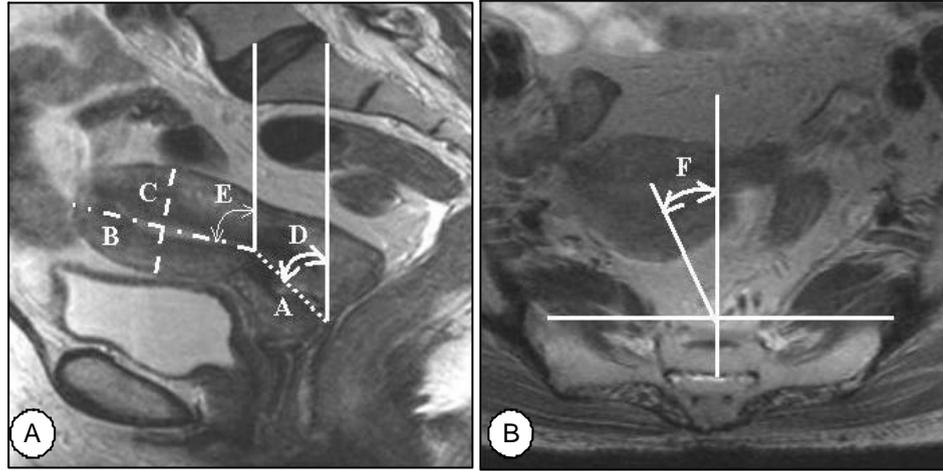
Sagittal and axial images on T2 weighted MRI showing the measurable parameters of the uterine corpus and cervix. (A) Dcx: the distance of the cervical canal. (B) Dco: the maximum length of the uterus corpus. (C) Dco - per: the maximum vertical distance of the uterine body. (D) Acx: the angle between the vertical line and the cervical canal. (E) Aco - ap: the angle of the uterine corpus from the vertical line. (F) Aco - axi: the angle of the uterine corpus from a fixed anatomical landmark.
